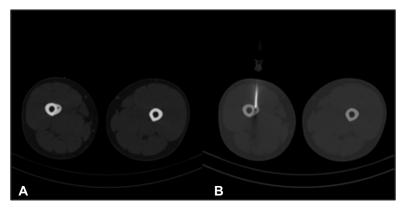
A) Axial CT scan image in bone window setting demonstrating nidus of Osteoid Osteoma B) Needle tip within the nidus of lesion by which alternating current is provided in form of radiofrequency
